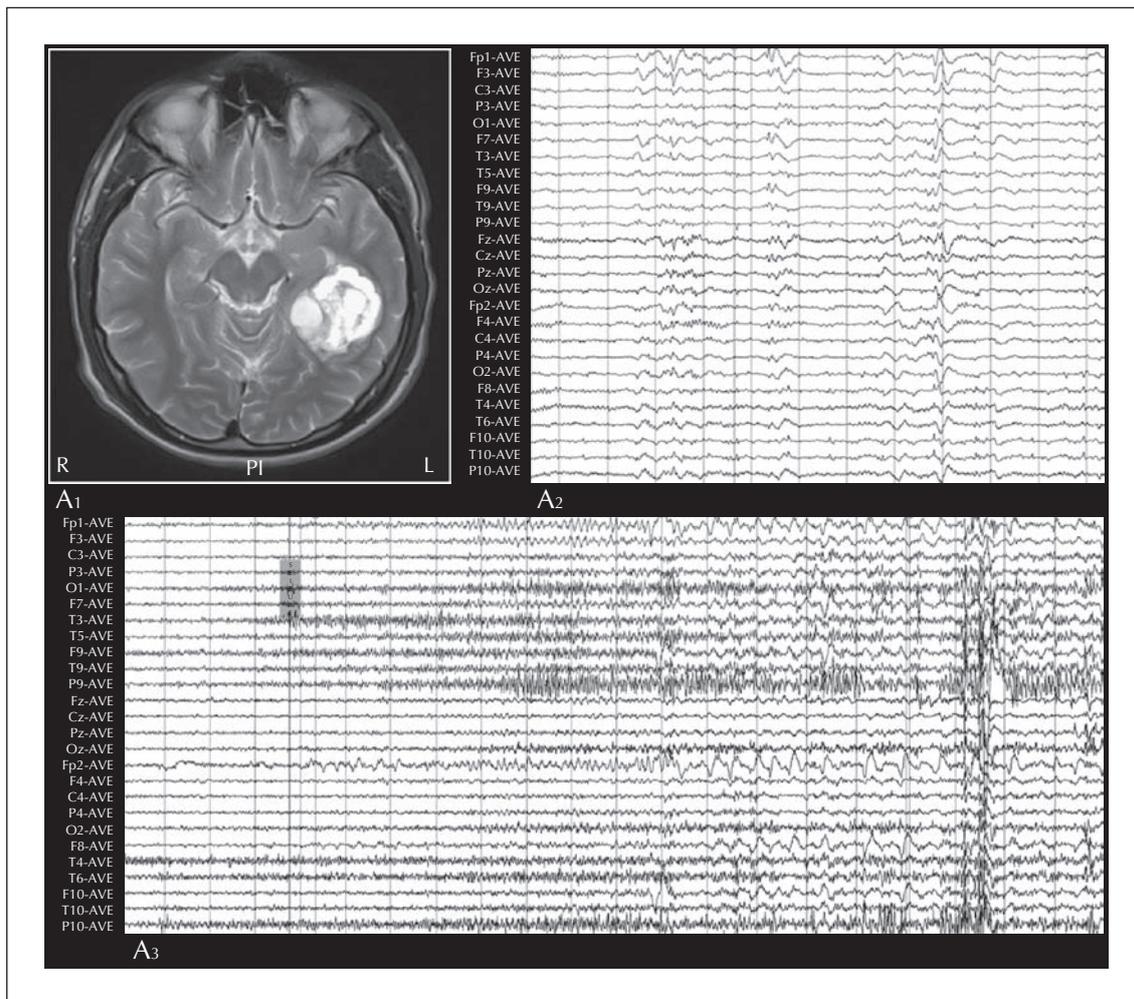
Patient 8. (A₁) MRI shows a left basal temporal cystic mass lesion. (A₂) Interictal EEG demonstrates a left frontotemporal interictal SW focus (Fp1/F3 spreading to F7/F9). (A₃) Ictal EEG reveals a low-amplitude fast rhythm localised over Fp1, spreading quickly to F3/F7 and Fp2.
